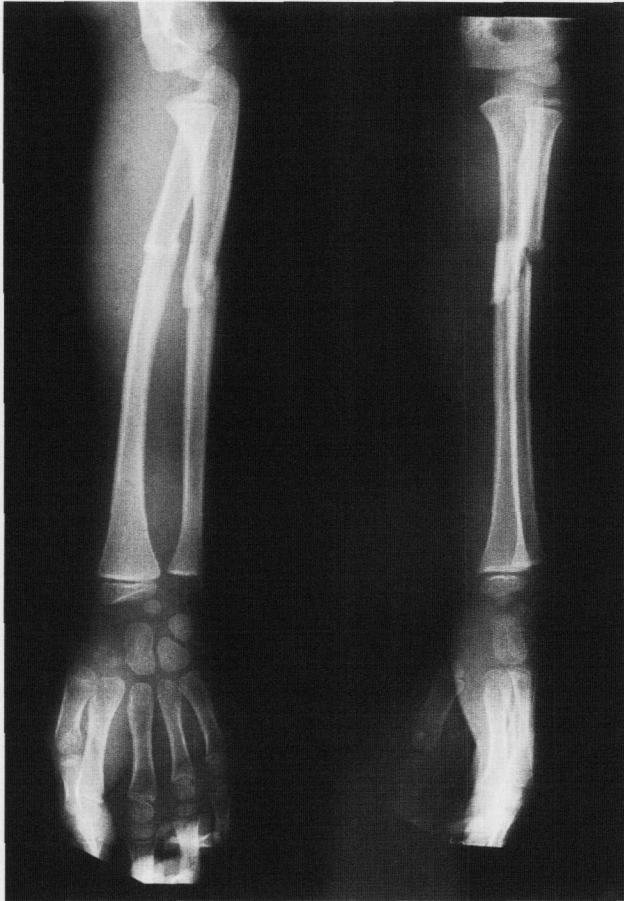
X-ray showing a closed fracture of both forearm bones with a significant soft tissue swelling.
